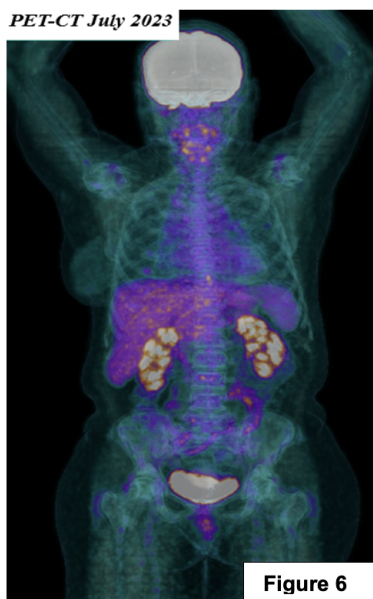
PET-CT with complete metabolic response.
